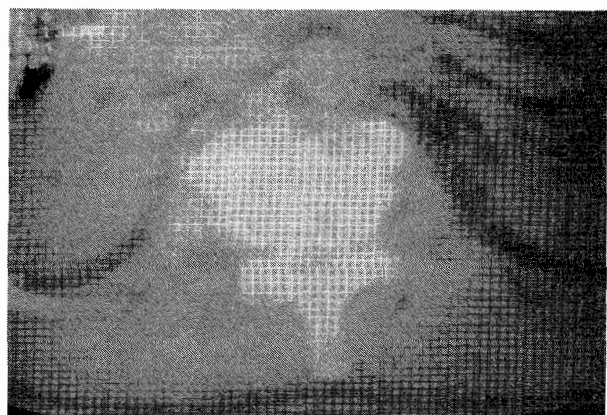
CT Lumbar spine showing sclerotic destruction of the vertebral body and anterior soft tissue
